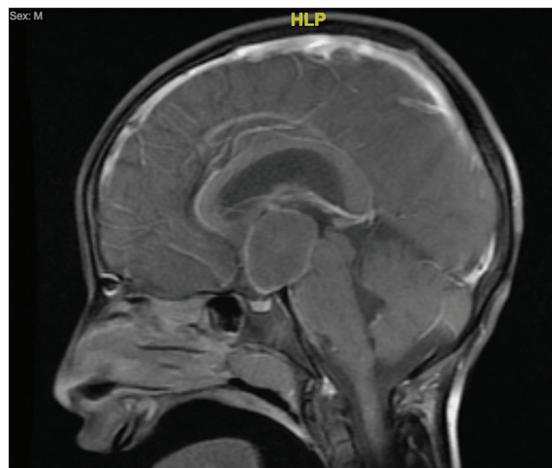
Magnetic resonance imaging of the brain, T1-weighted gadolinium-enhanced. Sagittal view, showing hypothalamic/suprasellar cyst, measuring $2.2 \times 2.3 \times 3.2$ cm in its maximum transverse, anteroposterior, and craniocaudal dimensions, respectively, with peripheral thin enhancement of the cyst and solid enhancement of the right inferolateral. HLP=head left posterior.
